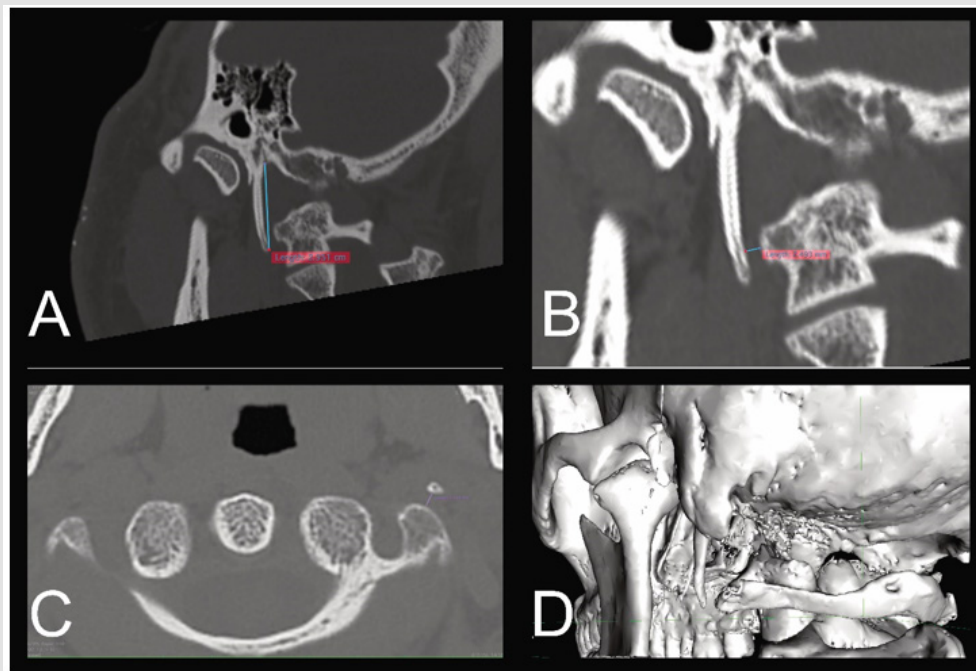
High-resolution computed tomography demonstrating abnormal styloid morphology despite a styloid length below the commonly used 3.0 cm threshold for elongation.
